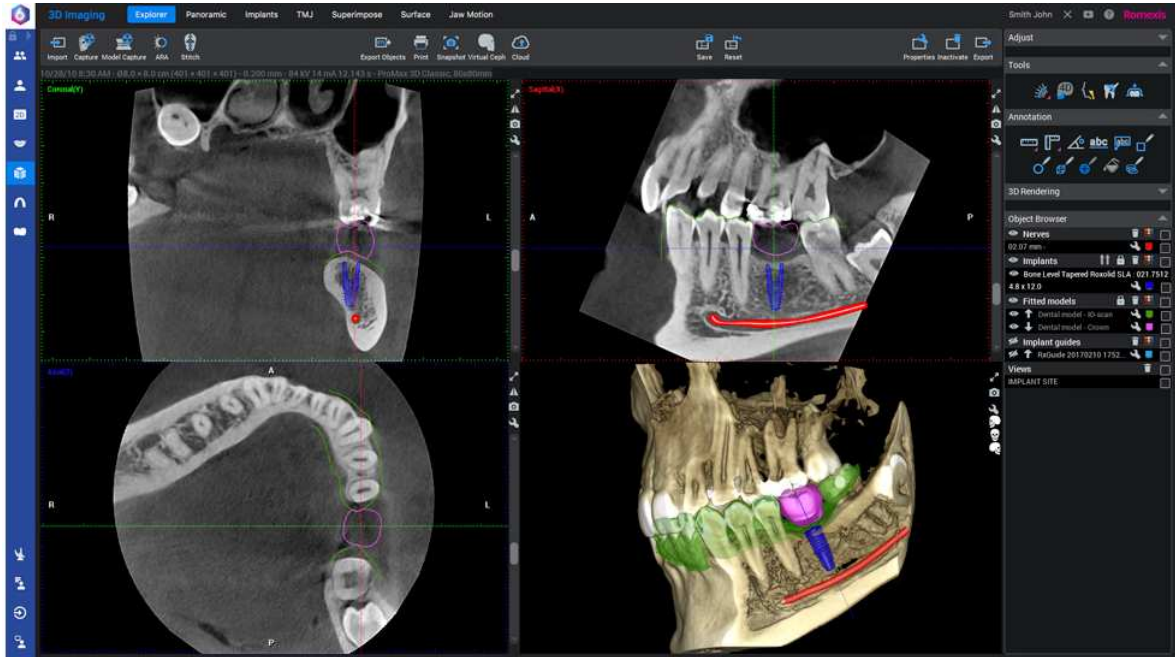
Implant planning in Planmeca Romexis software. Shown are the three anatomical planes of a CBCT image and a 3D render. The mandibular nerve is shown in red, the surgical guide in green, the crown of the implant in purple, and the screw in blue. Figure courtesy of Planmeca Oy, Helsinki, Finland.
